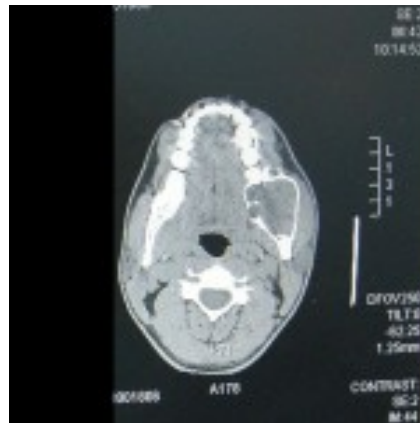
"CT-Scan" by Berto1286. License: Public Domain.
